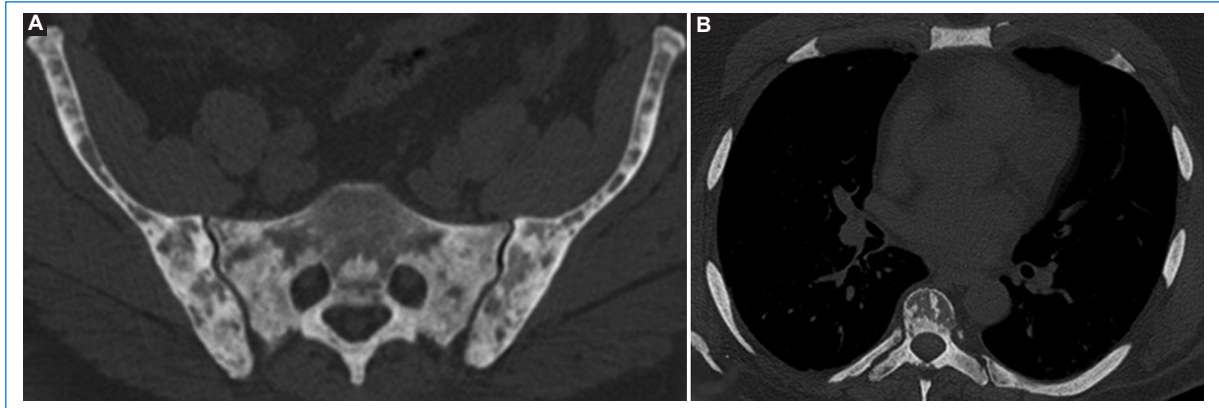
Axial CT of the pelvis (A) and thorax (B) with extensive heterogeneous increase in bone density in a patient with osteosclerotic myeloma.
